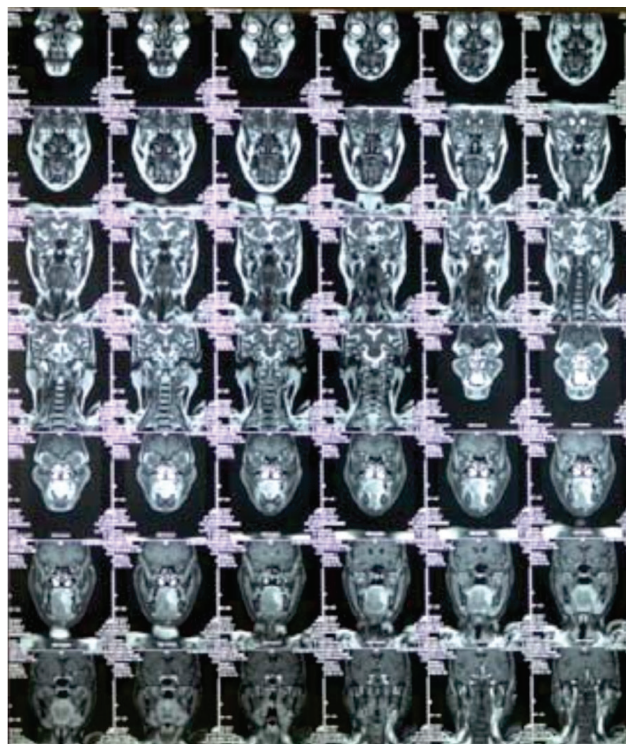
MRI of the patient in figs 10 & 11
